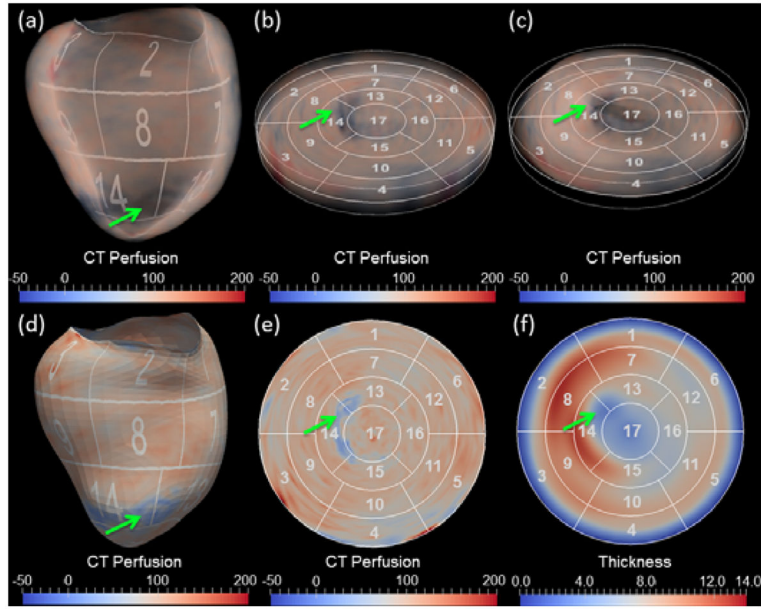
LV visualization using 3D volume rendering (top row) and 2D surface rendering (bottom row). In both cases, the LV is flattened from 3D (a, d) to 2D thick (b, c) or thin (e, f) slices in order to display the LV on the polar map. CT perfusion was rendered with uniform and absolute thickness in (b) and (c), respectively. The aggregated perfusion and thickness are shown in the (e) and (f), respectively. The green arrows point to the perfusion and myocardial thickness abnormalities.
